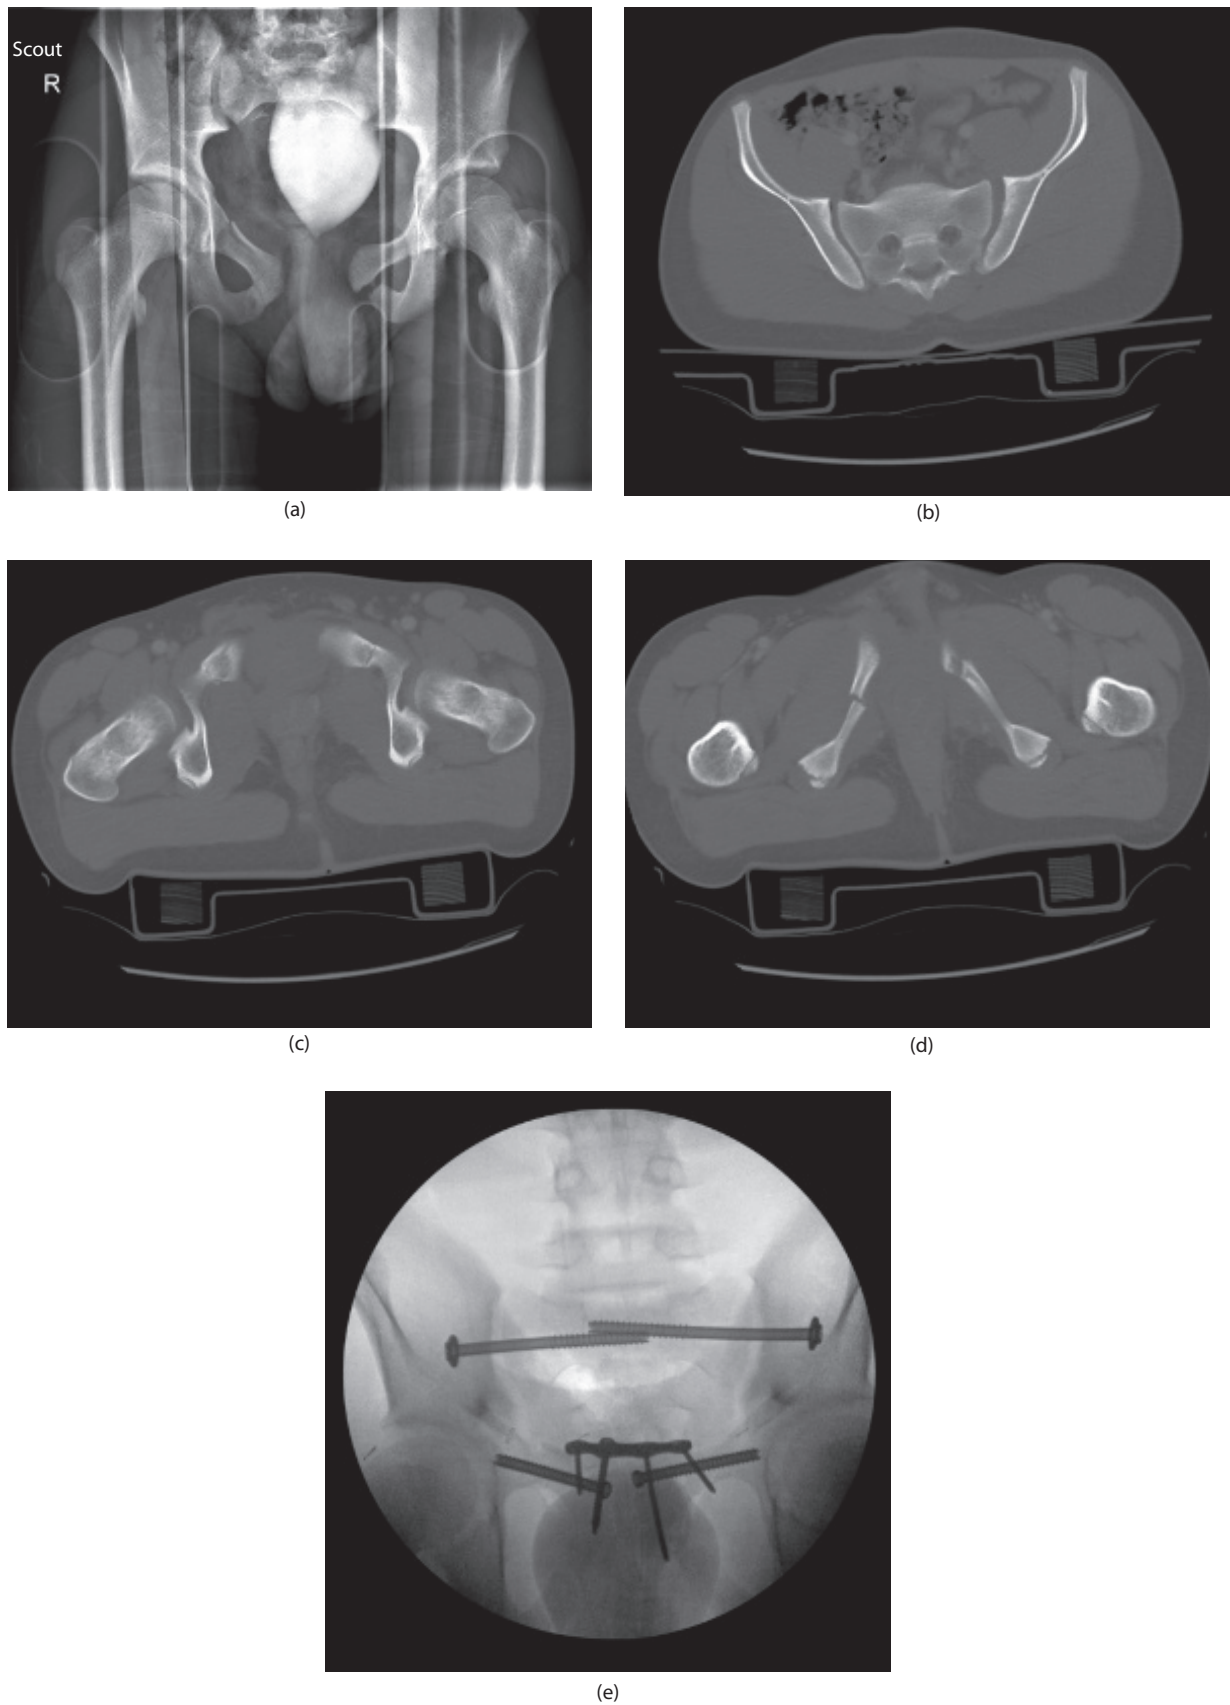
A 13-year-old male who sustained an unstable pelvic fracture after falling off a play structure from 30 ft. (a) Injury pelvic x-ray. (b–d). Injury CT scans demonstrating anterior and posterior pelvic widening. (e) Postreduction and fixation x-ray.
